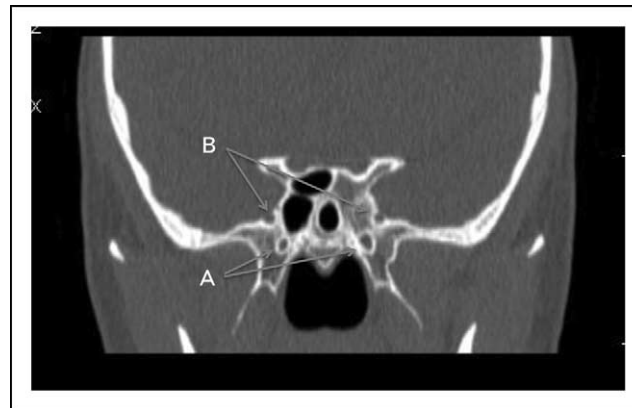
Coronal computed tomography scan demonstrating vidian nerve (a) and V2 (b) in the sphenoid sinus.
